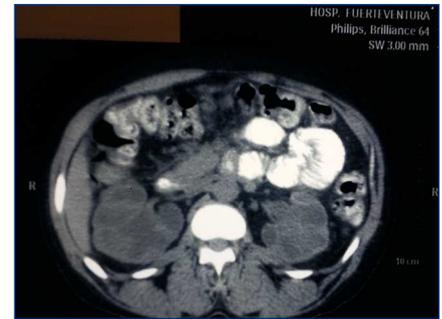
CT cut where bilateral hydronephrosis can be seen.
